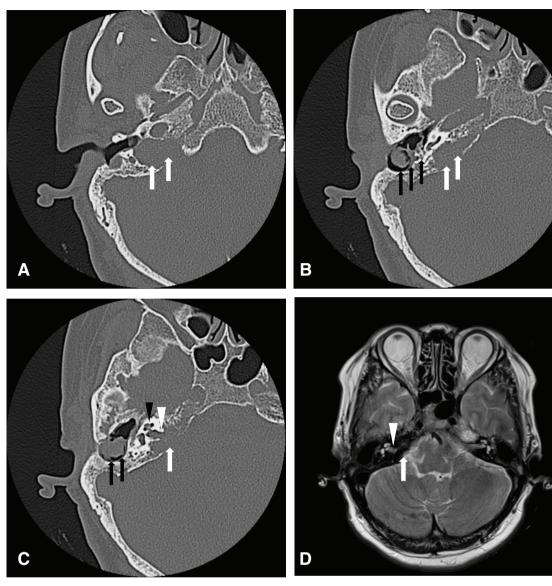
(A-C) CT shows the partial osteolysis of the right petrous bone (white arrows) involving the internal auditory meatus (white arrowhead) and the previous operative site for cholesteatoma (black
